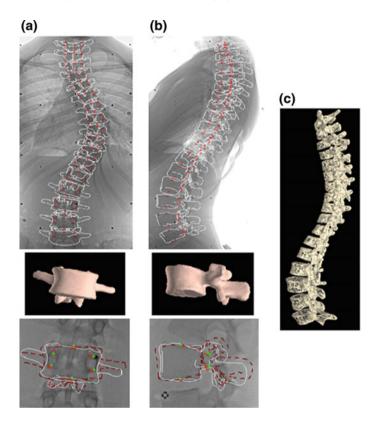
Results obtained on a a coronal and b sagittal X-ray image. Comparison of landmark and projected contours results from the manual technique (*square/dashed line*) and the proposed method using 3D deformable vertebra models (*cross/solid line*). c Final 3D reconstruction from the proposed method
